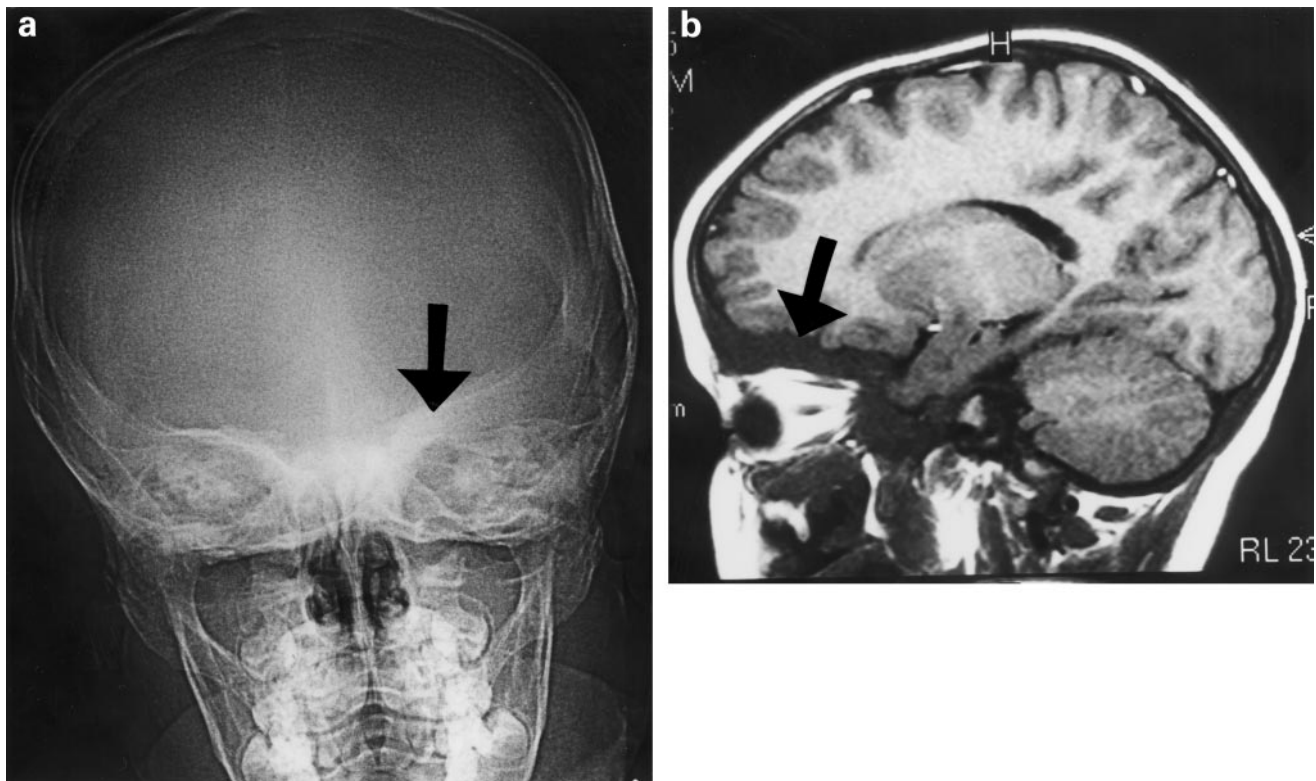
(a) Anterior–posterior view skull X-ray. Note the thickening of the sphenoidal wing on the left extending medially into the body of the sphenoid, typical appearances of fibrous dysplasia. (b) Magnetic resonance imaging scan. Sagittal T1 image of the brain. Note thickening of the diploid space and the sphenoid bone extending over the upper portion of the right orbit and into the body of the sphenoid.
